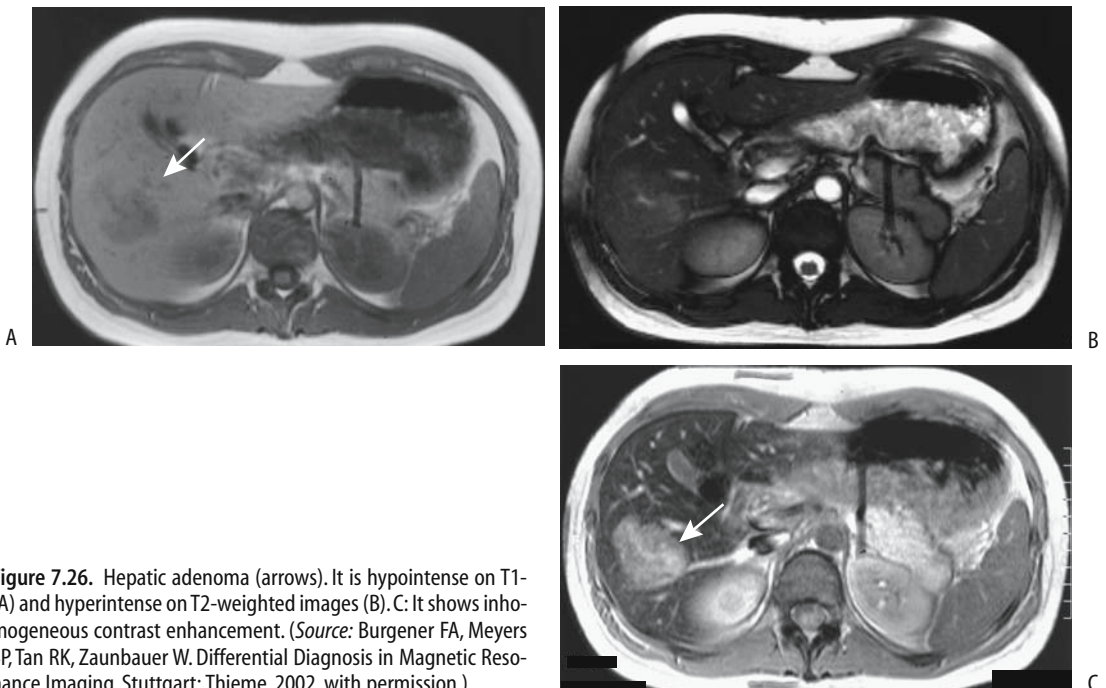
Hepatic adenoma (arrows). It is hypointense on T1-(A) and hyperintense on T2-weighted images (B). C: It shows inhomogeneous contrast enhancement. (Source: Burgener FA, Meyers SP, Tan RK, Zaunbauer W. *Differential Diagnosis in Magnetic Resonance Imaging*. Stuttgart: Thieme, 2002, with permission.)
